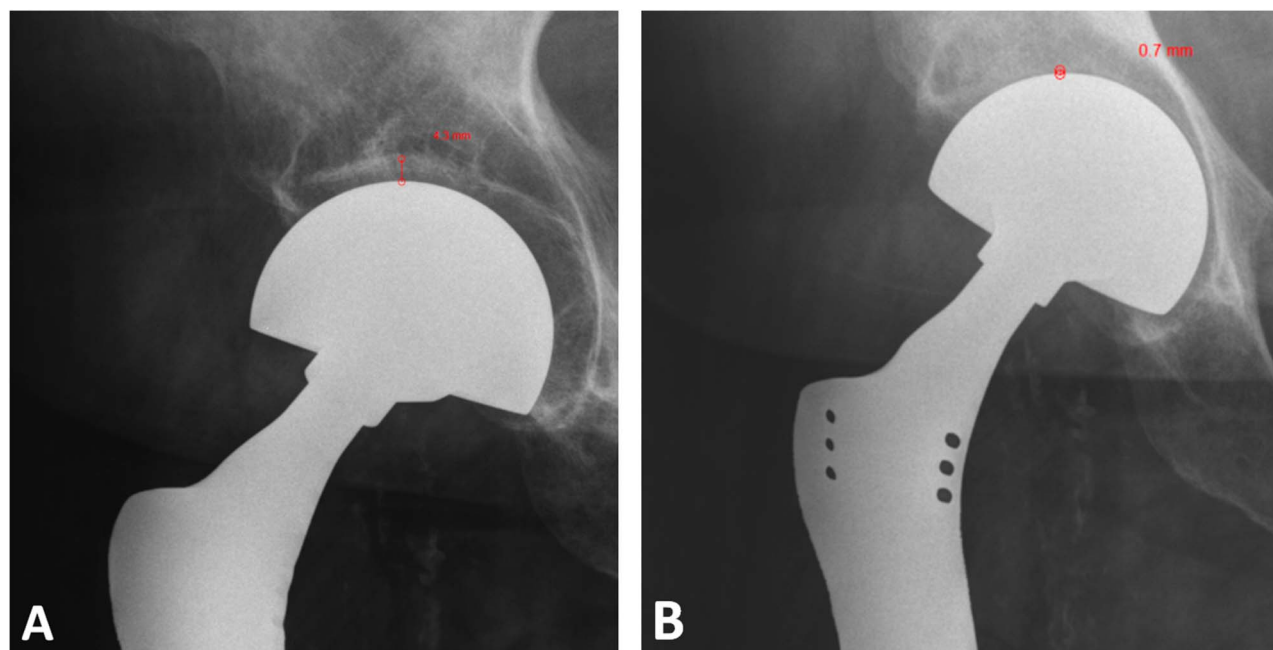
The images show magnification-corrected AP hip radiographs from a patient (A) immediately after surgery and (B) 7 years later. Measurement of the acetabular cartilage thickness postoperatively was 4.3 mm; however, this decreased to 0.7 mm at last followup, a 3.6-mm change.
